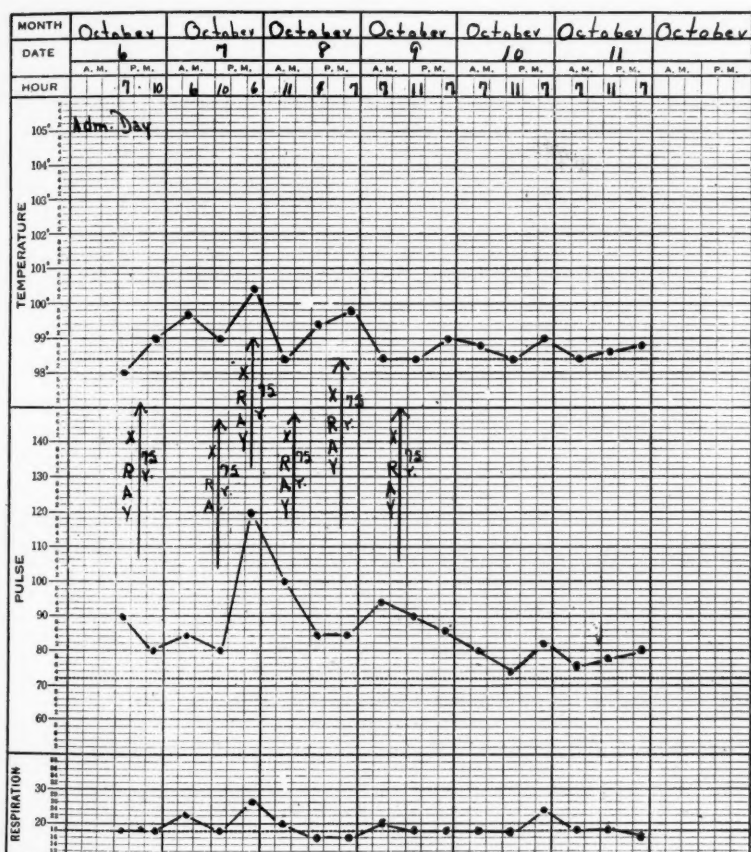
Case 1: Severe hand injury treated prophylactically with x-rays.
